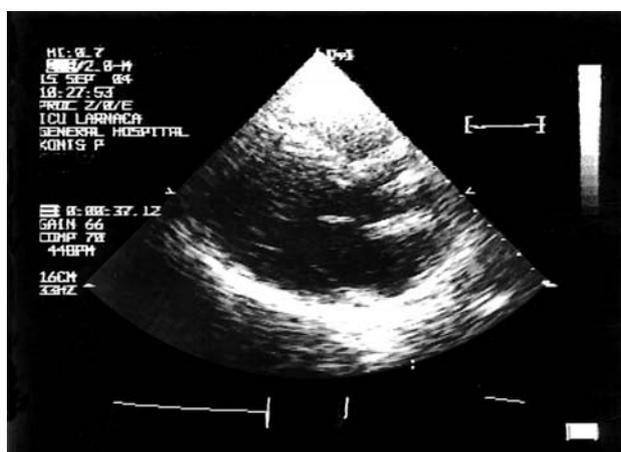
Transthoracic echocardiogram (parasternal long axis view) showing slight thickening of the anterior mitral valve leaflet with no significant pathology.
